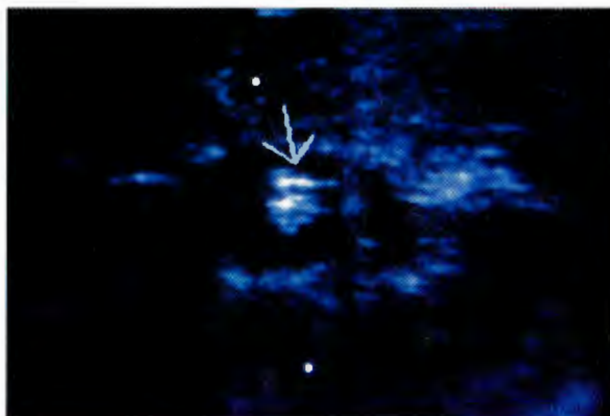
Left kidney ultrasound depicting a spherical echogenic image in the absence of a sonic shadow in the calices; focal caliceal dilatation is present.
